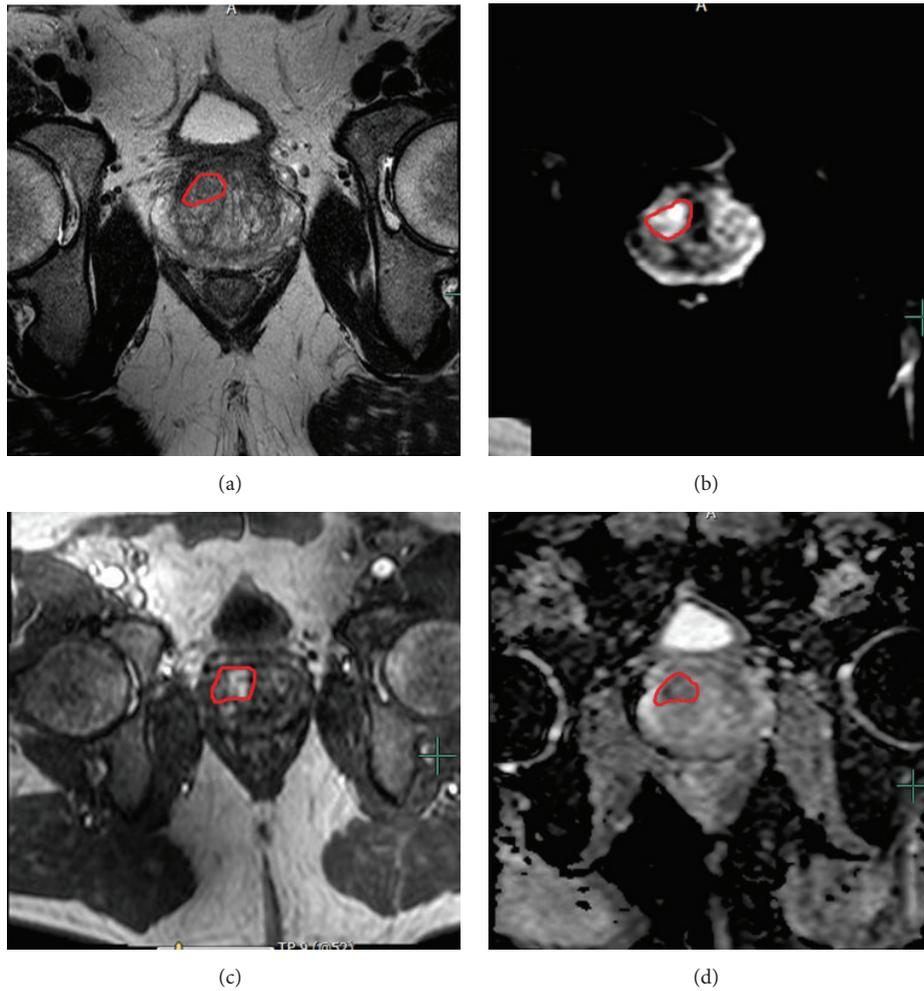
Multiparametric MRI evaluation and MRI-TRUS fusion biopsy in patient with multifocal intraprostatic lesions. The index lesions based upon MRI were identified in the right mid anterior central gland as an area of (a) T2 hypointensity, (b) increased signal on high  $b$ -value DW-MRI, (c) early enhancement on DCE-MRI, and (d) diffusional restriction on ADC map of DW-MRI. The right mid anterior central gland lesion demonstrated Gleason 3 + 4 disease on fusion biopsy. A second right base posterior peripheral zone lesion demonstrated Gleason 3 + 3 disease.
